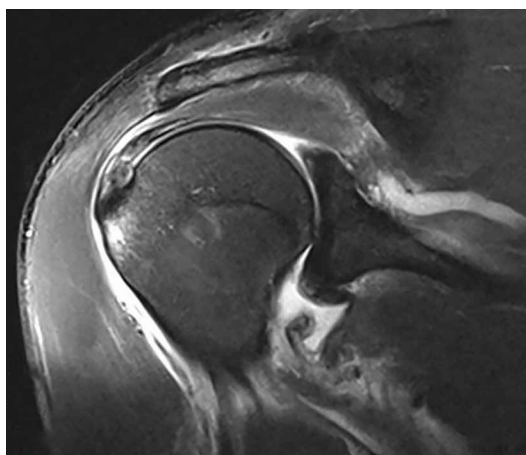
Coronal T2-weighted fast spin-echo magnetic resonance imaging with fat suppression shows humeral avulsion of glenohumeral ligament lesion at 5 o'clock position, partial tearing of infraspinatus, and greater tuberosity contusion.
